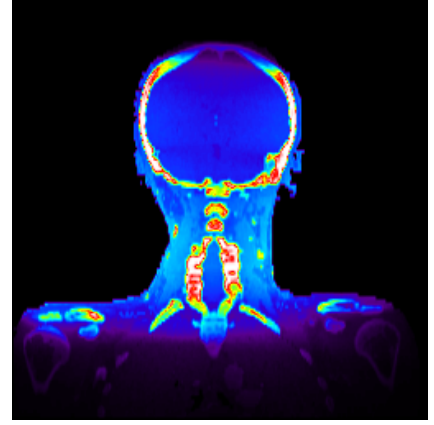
Isocentric slices for Pat. A for a cone beam CT acquisition (360° tube rotation). The slice positions are marked in the CT-slices shown in (n) - (p).
